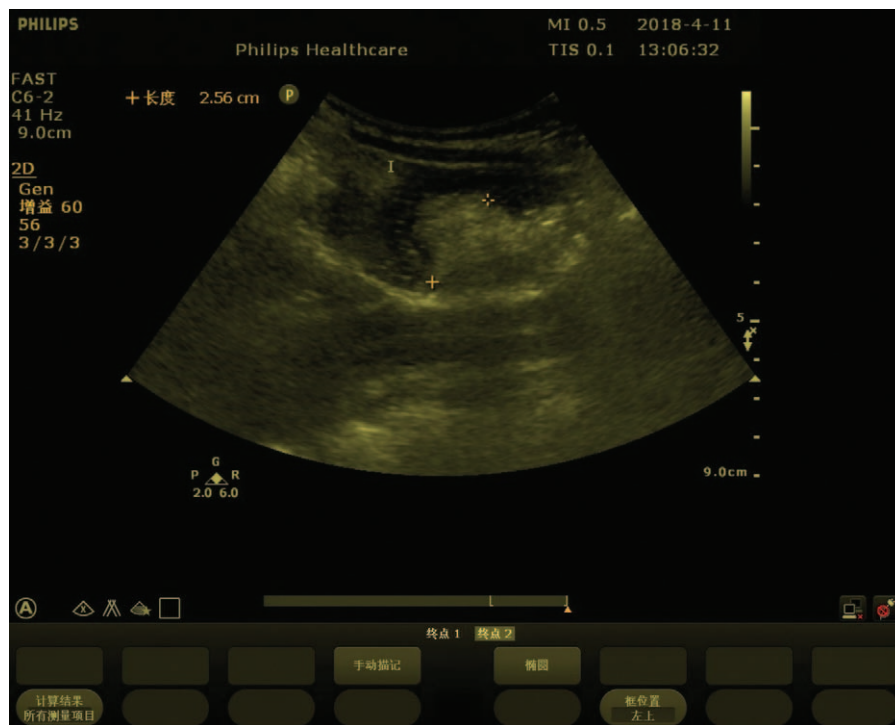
Abdominal ultrasound on the 12 h of admission, demonstrating a 2.56 cm thickness in mesentery of the right quadrant.
